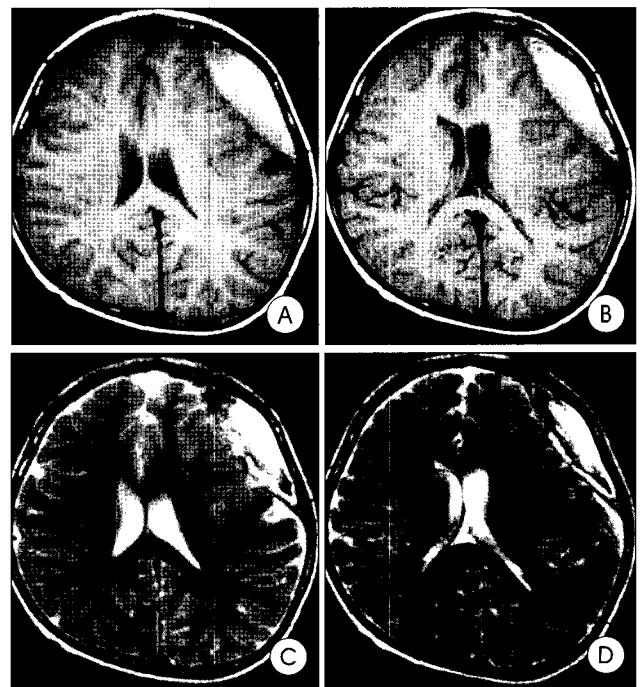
A, B, C, D Axial T1-weight & T2-weight magnetic resonance images demonstrate heterogeneous hematoma with calcifications over the left cerebral convexity.
